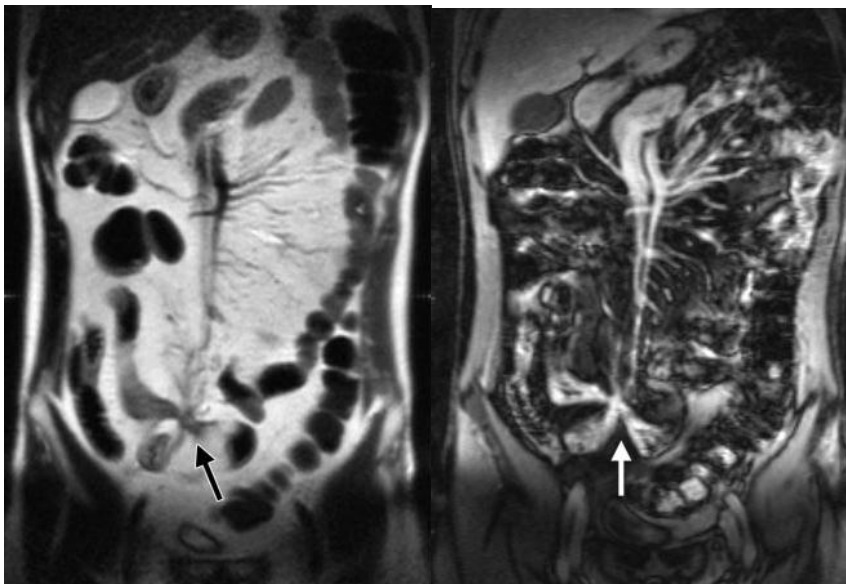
MR Images show recurrence of Crohn disease in a 52-years old man who underwent resection of the terminal ileum and descending colon 12 years earlier; this patient had a low level of biologic disease activity (negative ESR, CRP level, and WBC count) but positive clinical indexes of activity (ie, CDAI \square 150). (a) Coronal T2-weighted RARE image obtained after oral administration of a negative contrast agent. Recurrent Crohn disease at the level of the anastomotic ileal loop is clearly evident (arrows); the affected bowel loop shows thickened walls, reduced and irregular lumen over approximately 20 cm, and mild bowel dilatation above the stricture. Marked mesenteric fibrofatty proliferation (\square) is also evident, separating the affected bowel segment from the adjacent normal ileal and jejunal loops. (b) Coronal FLASH T1-weighted MR image obtained after intravenous injection of gadolinium-based contrast material. Diffuse wall thickening, increased wall enhancement, and lumen stenosis were observed at the level of the ileal anastomotic loop, suggesting recurrent Crohn disease (arrows). Bowel dilatation above the stricture is, however, less evident on this image than on the corresponding T2-weighted image. (c) Image obtained at follow-through barium examination shows a long inflammatory stricture (arrows) at the level of the anastomotic ileal loop. Marked fibrofatty proliferation is possible owing to separation of the affected bowel segment from the normal ileal and jejunal loops. (d) Transverse T2-weighted RARE image shows wall thickening at the level of the anastomotic loop (arrow) and inhomogeneity and increased volume of the peri-visceral fat tissue, which separates the affected loop from the other ileal loops. (e) Transverse fat-suppressed T2-weighted fast spin-echo image obtained at the same level. The T2-weighted signal intensity of the wall (arrow) is moderate; no signal intensity is evident at the level of the fibrofatty proliferation; this finding suggests the presence of chronic moderately active disease. (f) Transverse fat-suppressed T1-weighted FLASH image obtained at the same level. Layered wall enhancement (arrow) is evident, as is dilatation of the mesenteric vessels. These findings are suggestive of chronic moderately active disease.
